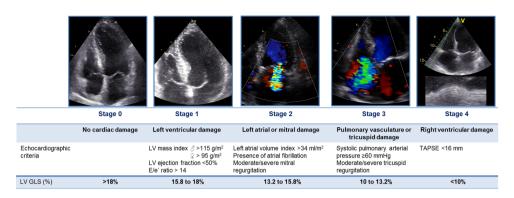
Proposed staging classification according to the presence and extent of cardiac damage on echocardiography with addition of LV GLS quintiles for reclassification. GLS, global longitudinal strain; LV, left ventricular; TAPSE, tricuspid annular plane systolic excursion.
